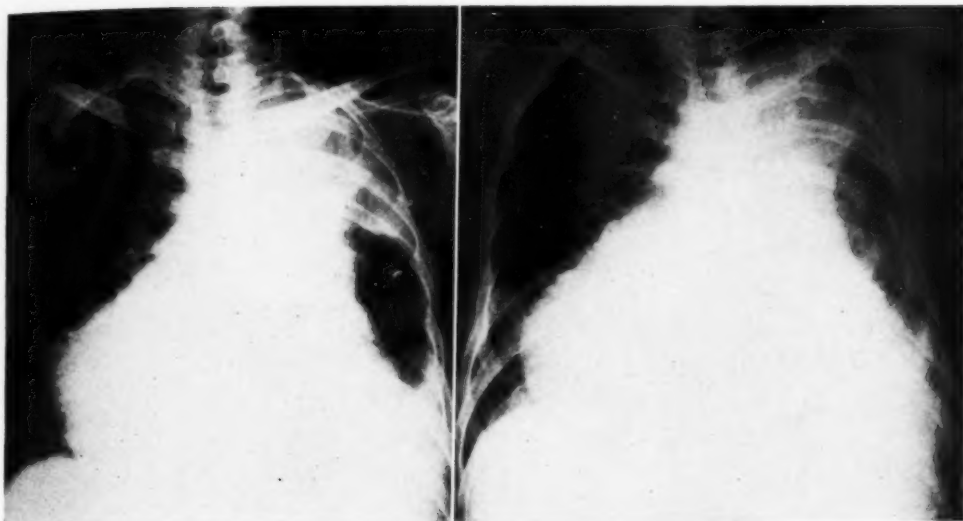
(left). Roentgenogram made Feb. 26, 1942, two and a half years after irradiation, showing slight diminution in the consolidation of the left upper lobe. The blunted left costophrenic angle persists. The trachea remains unchanged. The cardiac silhouette is now tremendous, extending far to the right of the mid-line. It was thought at the time that the patient was suffering from metastatic carcinoma. Now for the first time the thinning of the ribs along the lateral chest wall is demonstrated.
